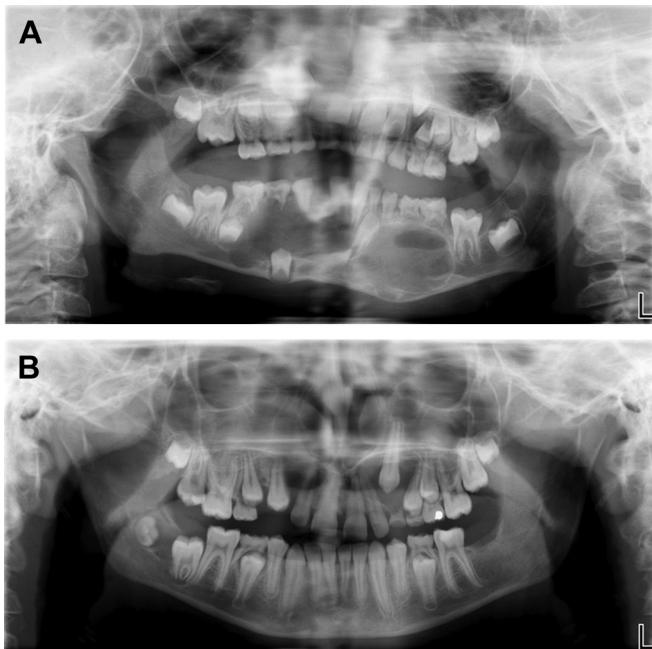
(A, B) Panoramic radiographs of siblings with multiple OKCs as seen in Gorlin-Goltz syndrome.
